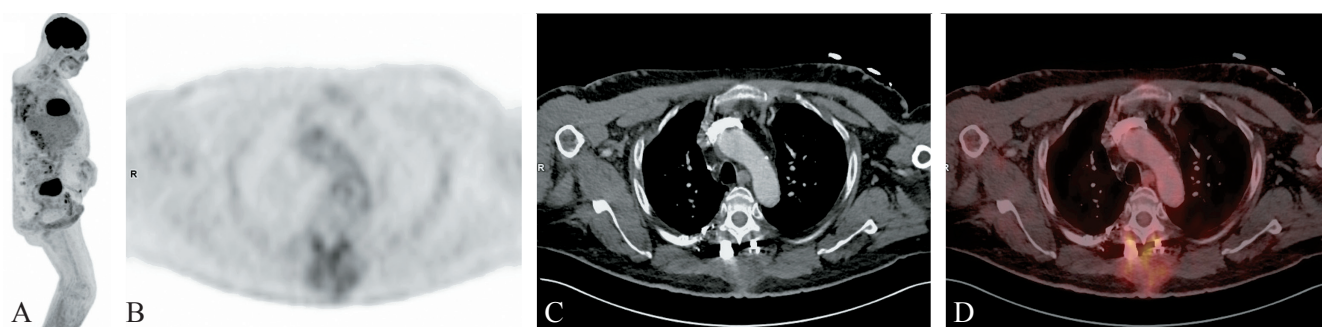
MIP image (A) and axial PET (B), CT (C) and PET/CT fusion (D) images showing dorsal paravertebral abscess formation where [^{18}F]FDG PET/CT helps guide biopsy in a *Staphylococcus aureus* infection.
